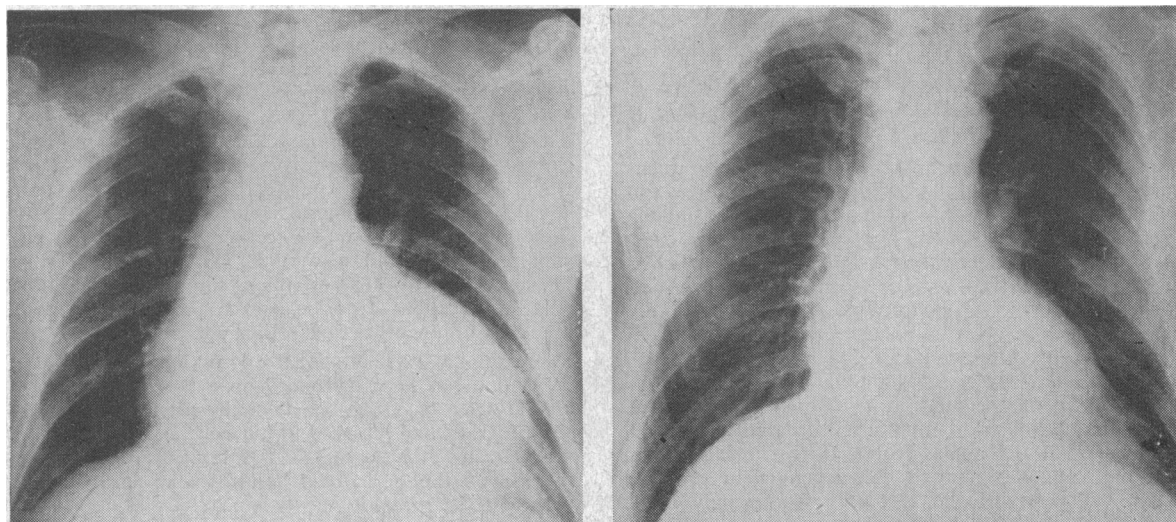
Case 1. Left, radiograph showing pericardial effusion. Right, radiograph taken 13 weeks later.
